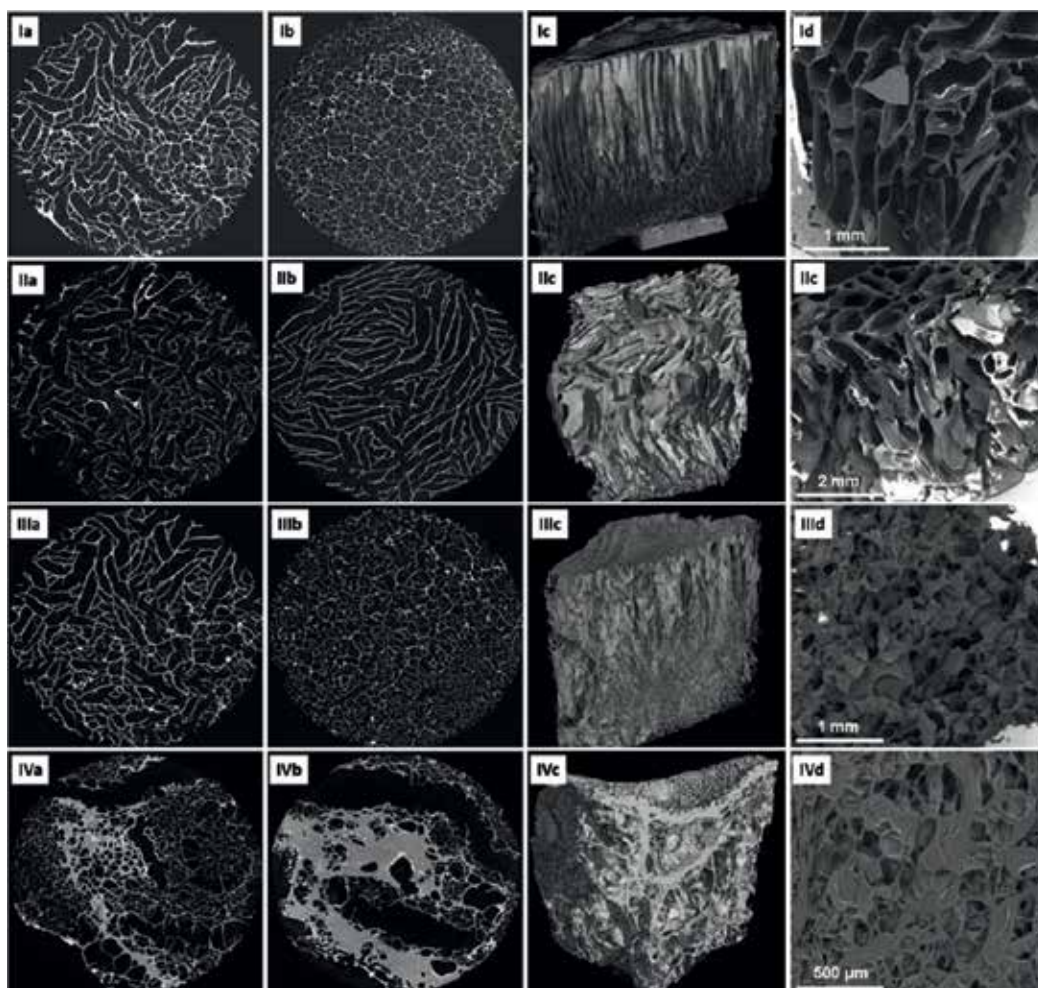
Morphology of the gelatin-PHEMA porous scaffolds as obtained through μ -CT (panels (a)–(c): (a), top view; (b), bottom view; (c), side view) and SEM (panel (d)) analyses: panel (I), C0; panel (II), C1; panel (III), C2; panel (IV), C3. Reprinted with permission from Ref. [107].
